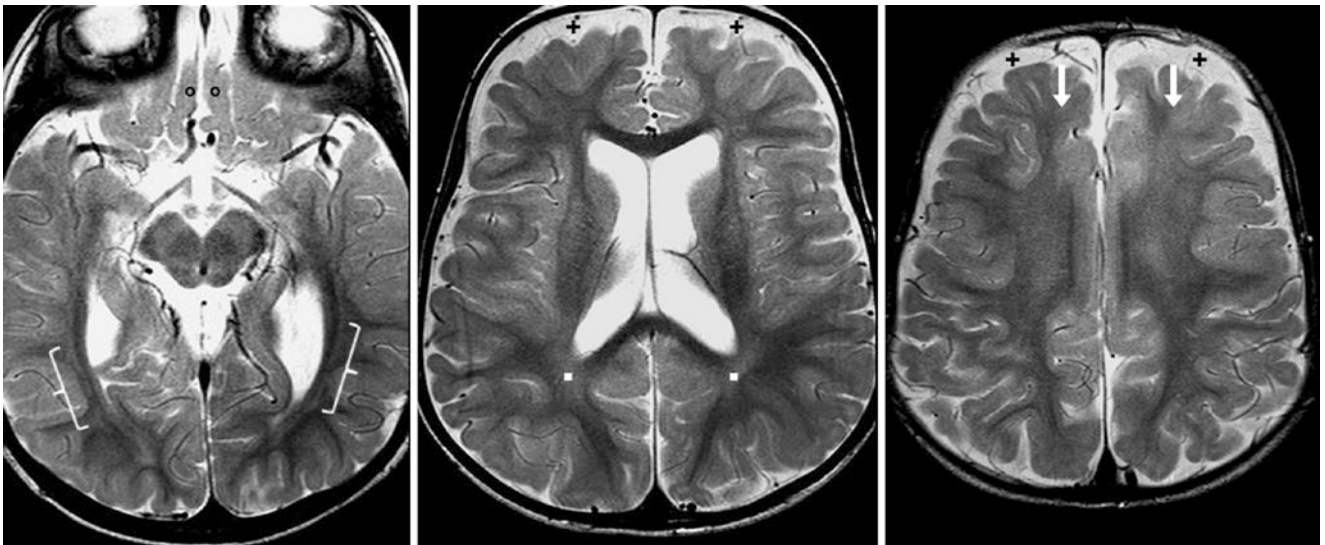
A 20-month-old who was neurologically normal had macrocephaly and benign enlargement of subarachnoid spaces (plus signs), with an otherwise normal 3T MRI. On SE T2WIs, note incomplete
